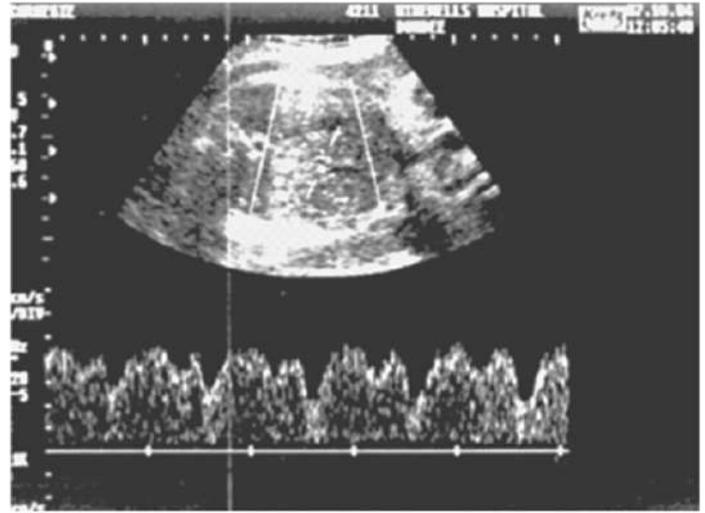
Normal ductus venosus Doppler waveform.
